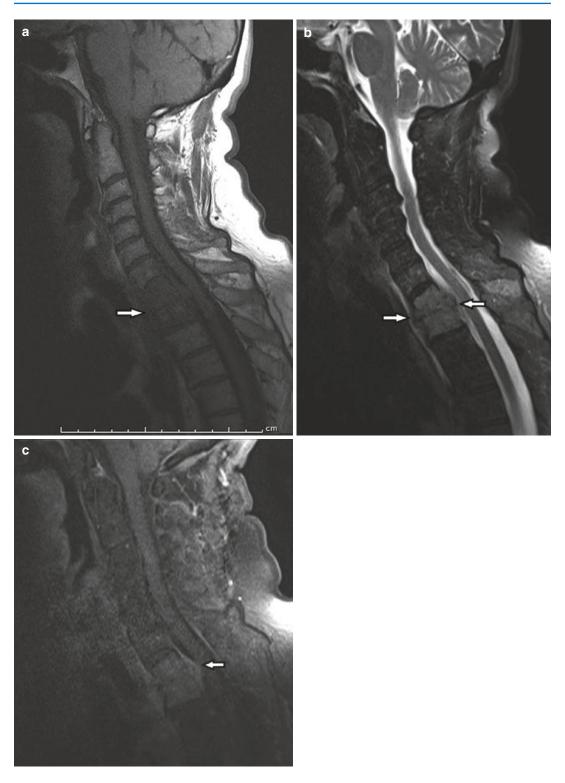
A 75-year-old woman. (a) Sagittal T1-weighted MRI shows heterogeneously hypointense signal (*arrow*) in T1–T2 vertebral bodies with epidural mass. (b) T1 and T2 vertebral bodies are heterogeneously hyperintense
